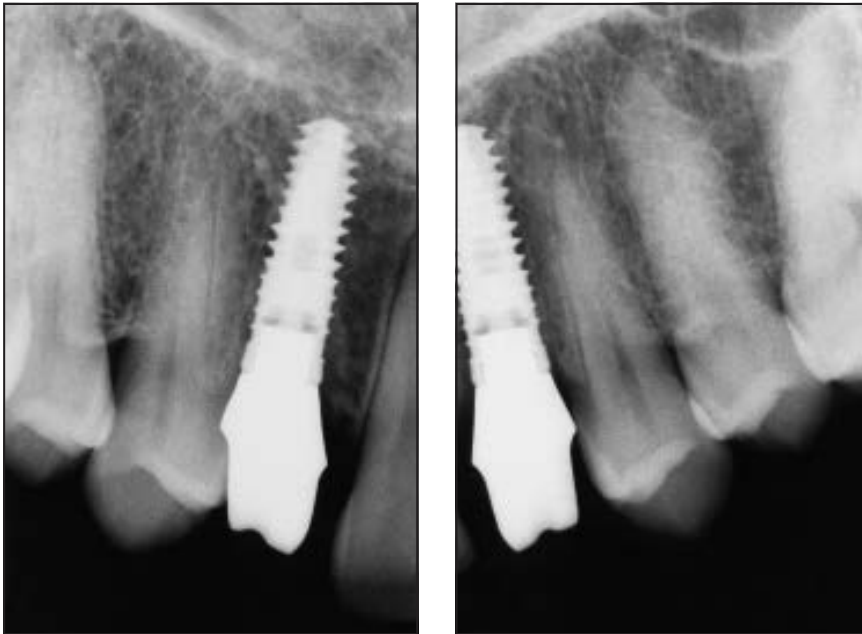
The final radiograph at 1 year after definitive crown cementation (2 years from implant placement) demonstrated functional implant integration.
